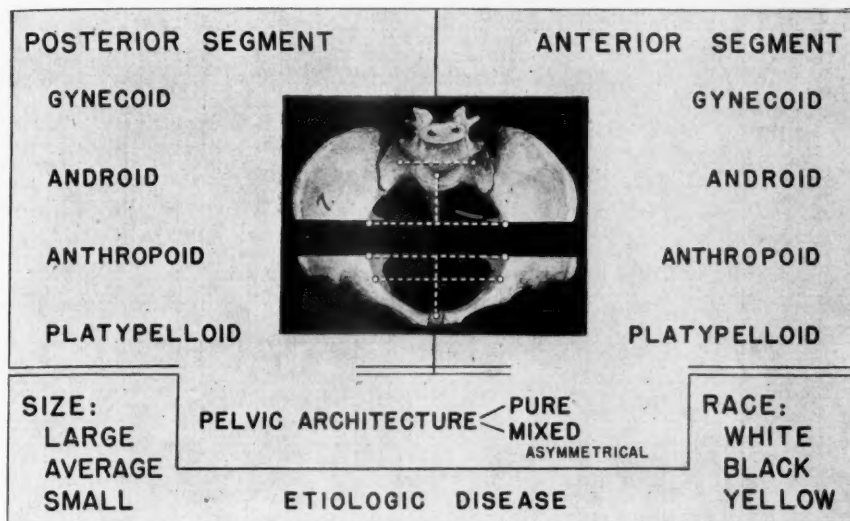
Classification of the obstetric pelvis based on mensuration and morphology (clinically and/or radiographically).
